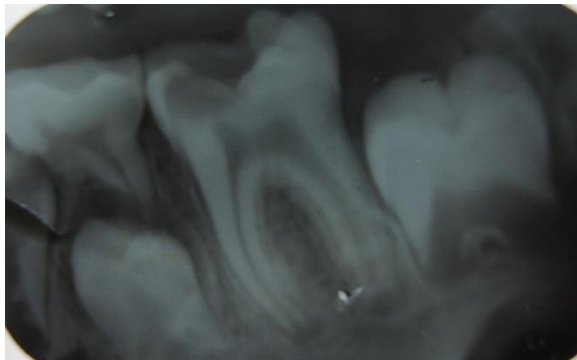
Preoperative radiograph showing carious 36, with open apices.
